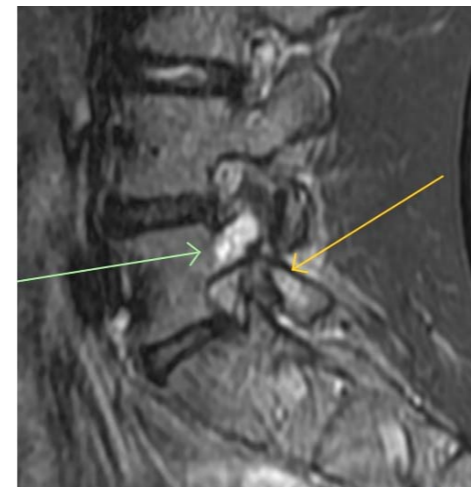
MRI Sagittal STIR. L5 pars stress reaction with bone marrow oedema.
